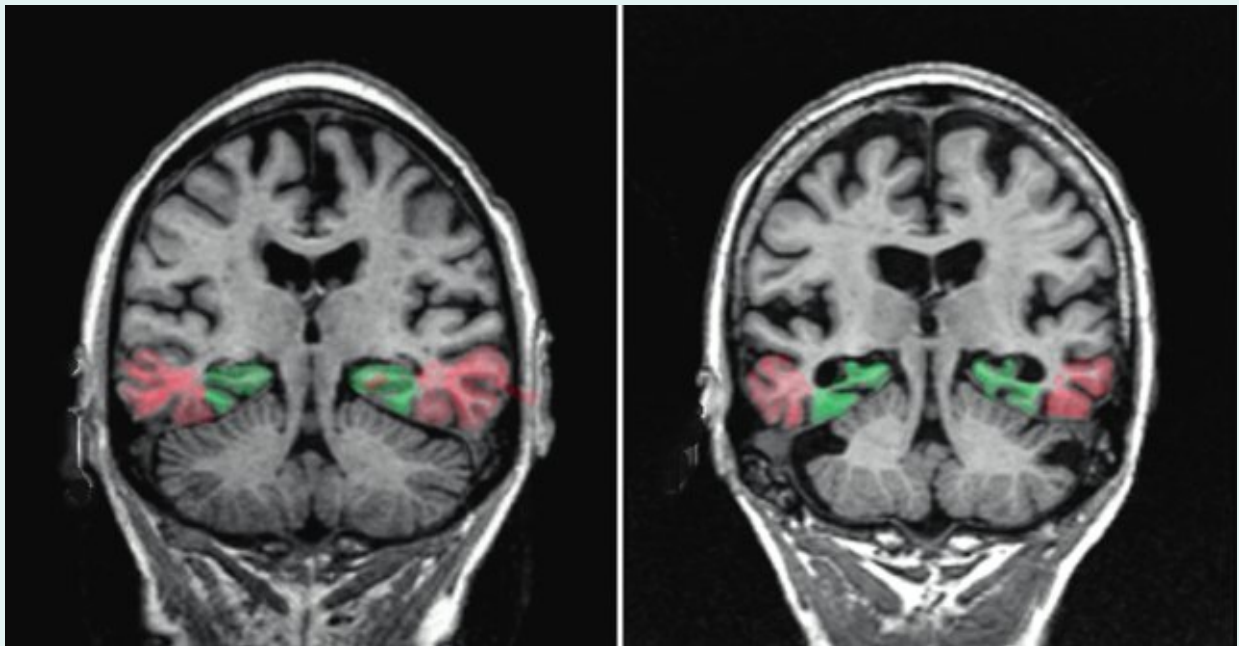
Coronal MRI slices. (A) Normal control. (B) Alzheimer patient. (Images supplied by Professor Clifford R. Jack, Jr., and the Alzheimer's Disease Research Center at the Mayo Clinic.) Colours added: green ¼ hippocampus; red ¼ entorhinal cortex.
